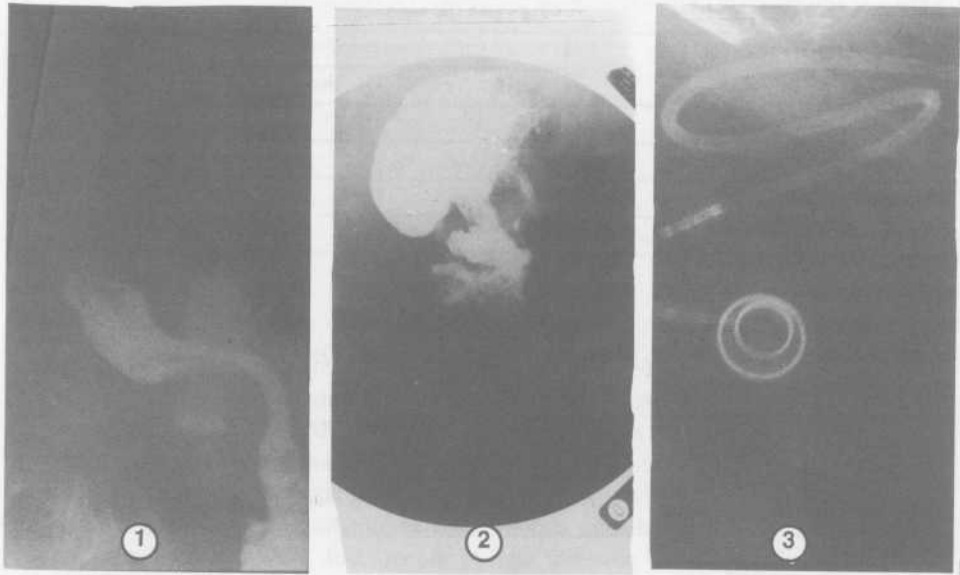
Plate 1. Barium meal showing the correction of the rotated band and repositioning of the slipped stomach. Plate 2. X-ray showing the rotated access port before correction. Plate 3. X-ray showing the rotated access port after correction.
